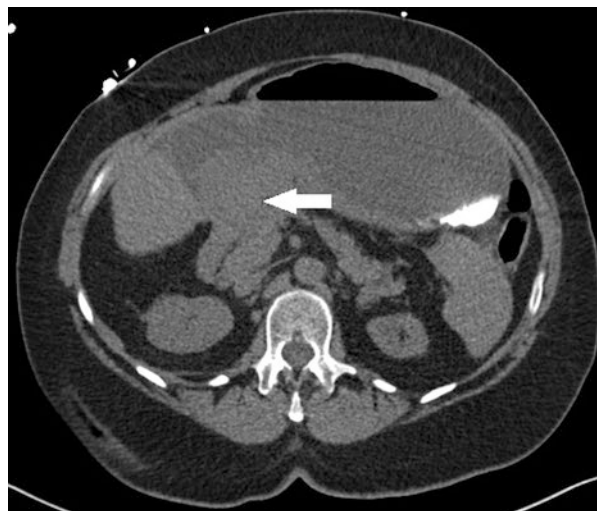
CT scan of a patient with GOO due to an obstructing pancreatic mass (arrow) with profound dilation of the stomach and well as duodenum
